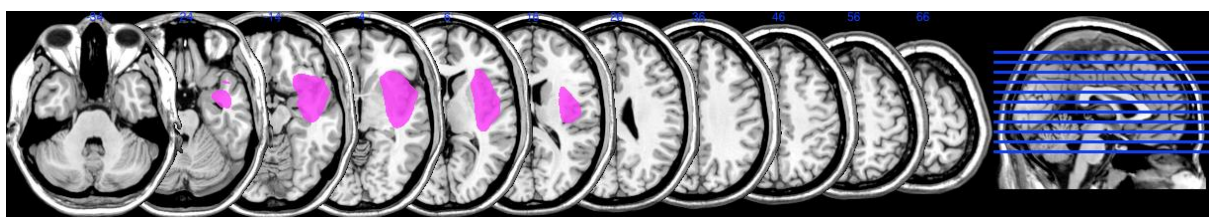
MRI scan of patient DF
